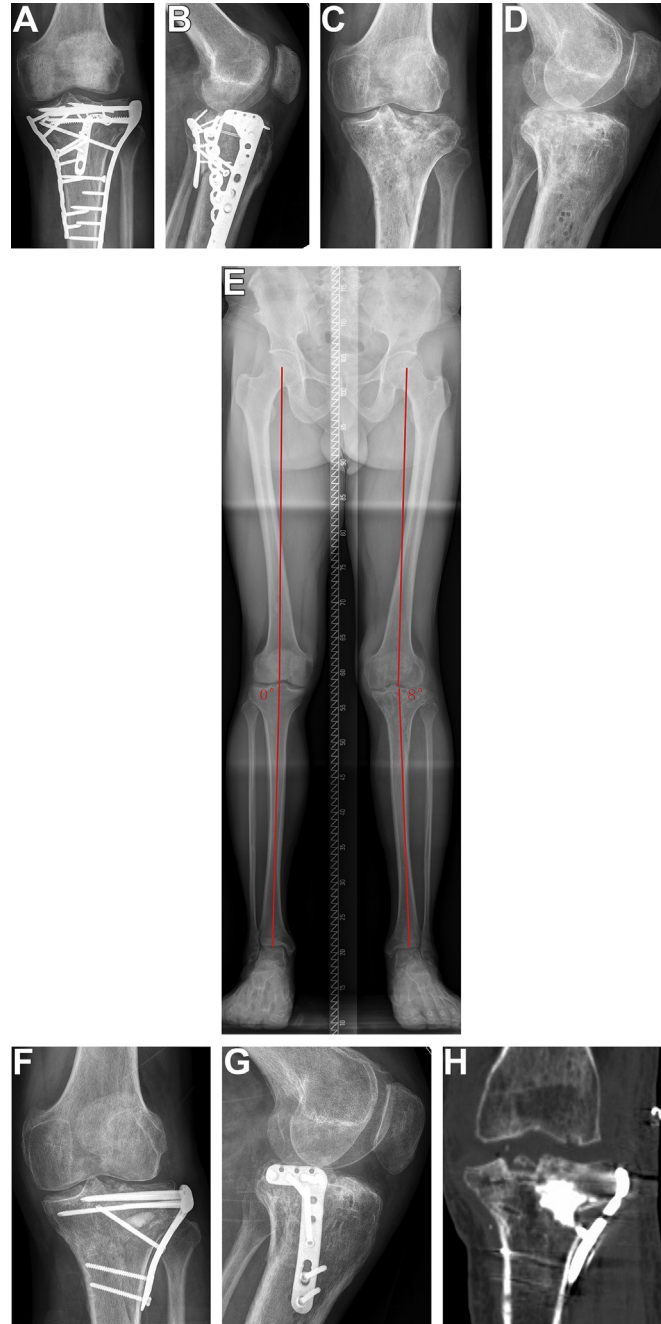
A 54-year-old woman with infection. (A–C) Preoperative X-ray showed that collapse of the lateral tibial plateau articular surface and obvious valgus alignment ( $5^\circ$  valgus). (D, E) Revision surgery was performed to remove the original internal fixation, reduce the articular surface, and perform external fixation treatment. (F, G) CT scan after revision operation showed 2 mm of articular surface collapse left.
